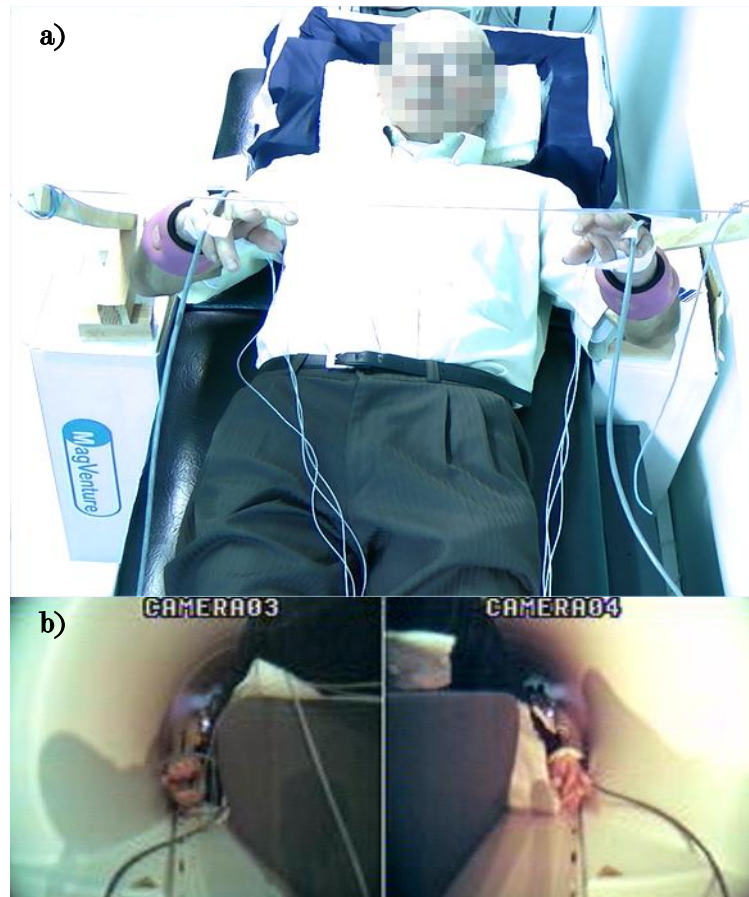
a) In the out-bore setup two wooden bars connected with a wire were placed along participants body in order to define arms rising up amplitude of 45° . All experiment was recorded using a video camera. Loads were added during the task. b) In the in-bore setup patients raised their arms up towards postural position, until the maximum range compatible with the space in the MRI scanner, between 30° to 40° . In-bore cameras were used to control the acquisition.
